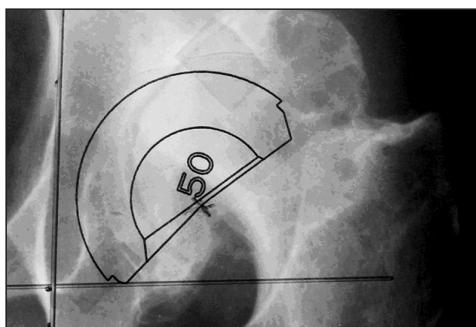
Placing the proper sized template as determined by the CT on the rotational center of the hip
